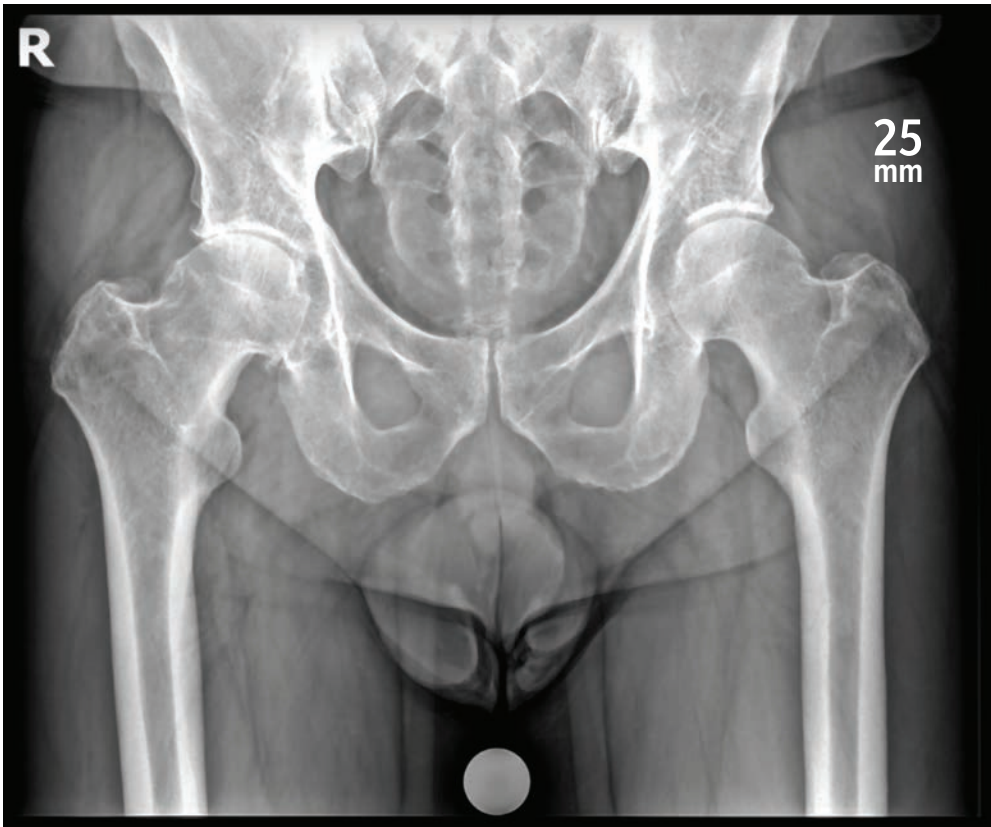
Preoperative Bilateral AP X-ray Example
